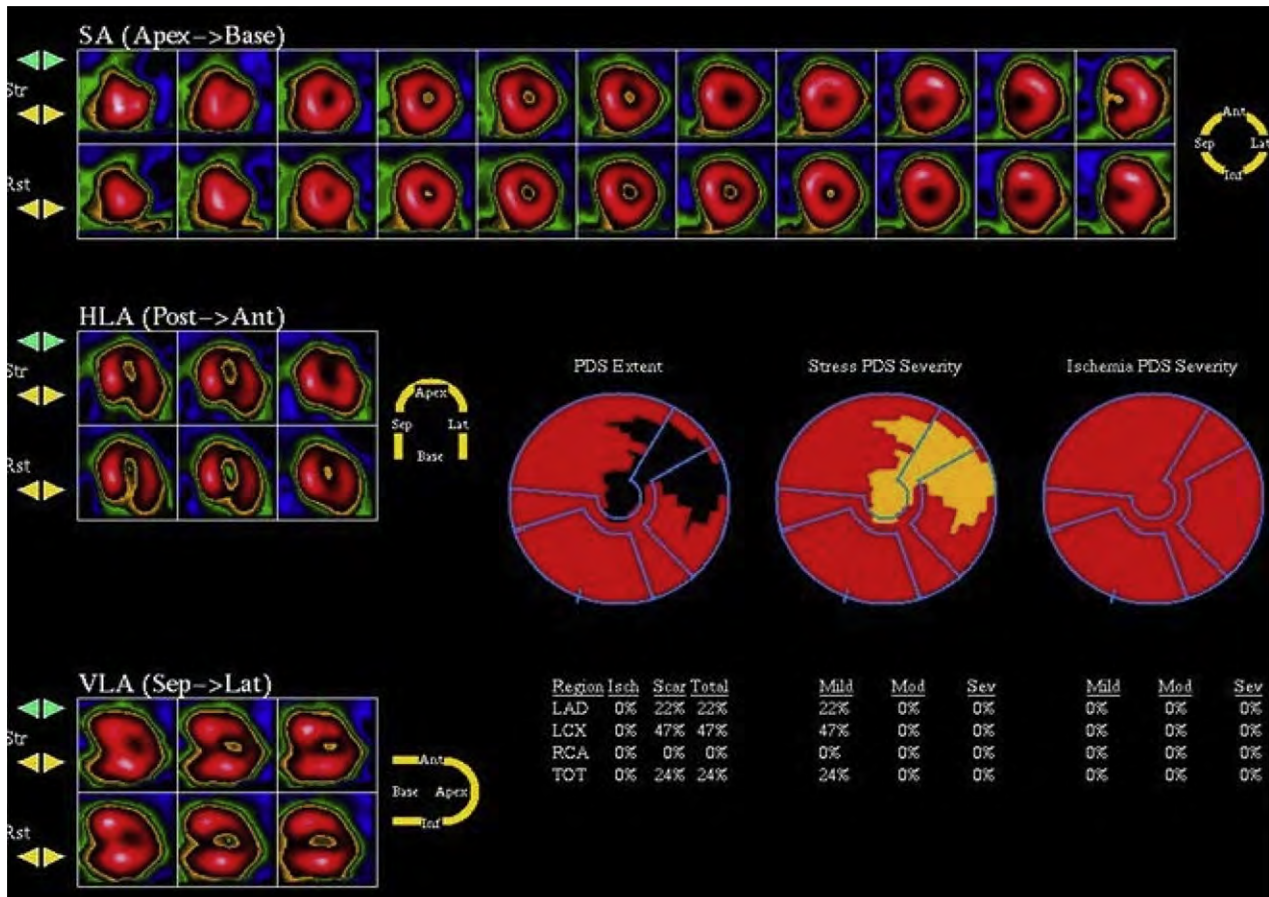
Single photon-emission computed tomographic perfusion imaging from a patient with HCM. Septal (Sep) thickness is increased, as is the count activity (*hot spot*) in the septum relative to lateral (Lat) wall. The computer analysis software registered a fixed perfusion defect (*scar*) (PDS) in the lateral and apical regions upon normalization to the septum. Ant, anterior; HLA, horizontal long-axis; LAD, left anterior descending coronary artery; LCX, left circumflex coronary artery; RCA, right coronary artery; TOT, total; VLA, vertical long-axis. Reproduced with permission from *J Am Coll Cardiol*.³⁹
